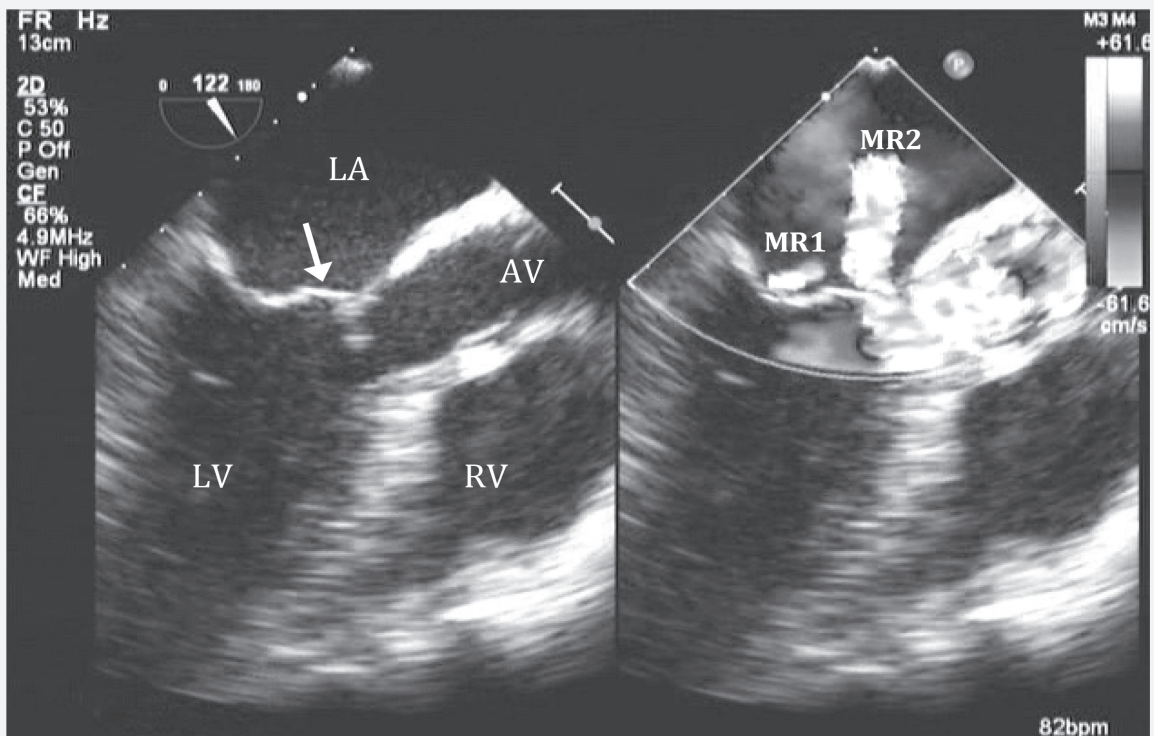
Transesophageal 2D echocardiography mid-esophageal long-axis view of the mitral valve demonstrating two regurgitant jets (MR1 and MR2) during systole, with predominant mitral regurgitation at the more anterior orifice due to prolapsing leaflets (arrow). Abbreviations: 2D, two-dimensional; AV, aortic valve; LA, left atrium; LV, left ventricle; RV, right ventricle.
